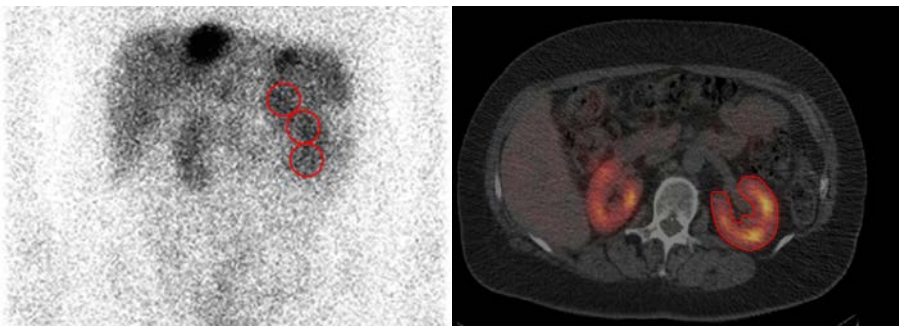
Images acquired during  $^{177}\text{Lu}$ -DOTATATE therapy of neuroendocrine tumours. Left: planar image with circles indicating ROIs placed at different positions over the left kidney. Right: reconstructed SPECT/CT image with VOI delineated over the same kidney. Courtesy of K. Sjögreen-Gleisner.
